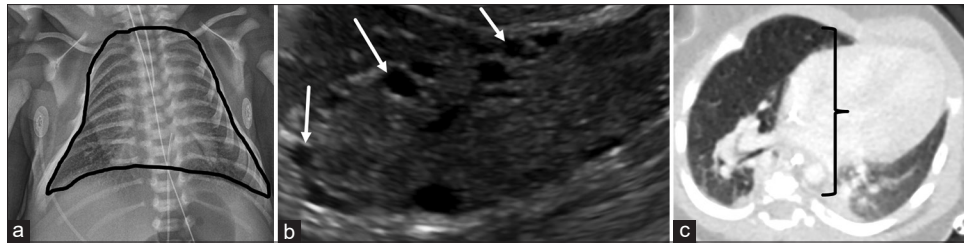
A 2-day-old male infant with cystic renal dysplasia presents with shortness of breath. (a) Chest radiograph shows hypoplastic lungs and a bell-shaped thorax (black outline). (b) Ultrasound of the right kidney in the sagittal view shows increased cortical echogenicity with multiple cortical and parenchyma cysts (white arrows). The left kidney is similar in appearance (not shown). (c) Axial chest computed tomography image shows disordered lung growth and reduced chest circumference (black bracket)
